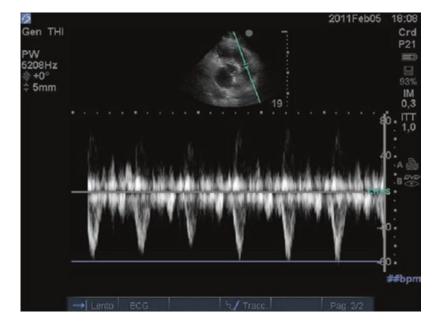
TTE and transesophageal echocardiography of the trunk of the pulmonary artery
